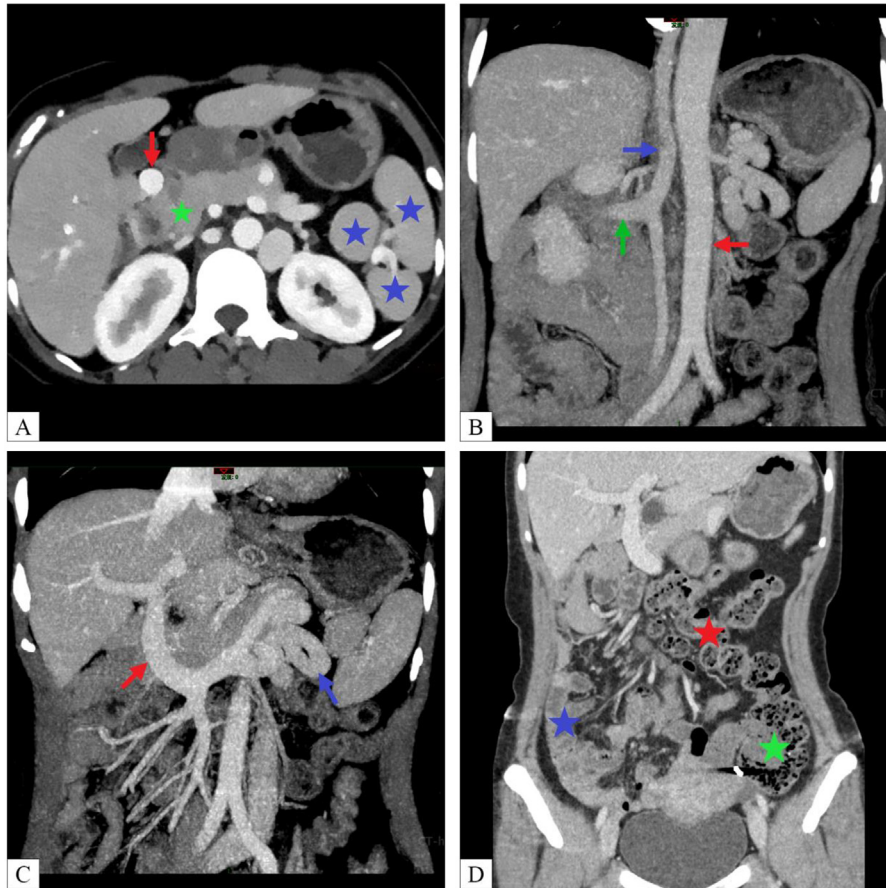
The patient’s abdomen CT scan images. (A) CT-enhanced Mono E40kev arterial phase image (axial plane). Multiple splenic nodules (blue stars) of varying sizes in the splenic area of the left upper abdomen. Part of the head and neck of the pancreas (green star) is hypertrophied and spherical, and the tail of the gland is short. The portal vein (red arrowhead) is located anterior to the duodenum. (B) CT MIP image (coronal plane). The right renal vein (green arrowhead) flows back into the azygos vein (blue arrowhead), and the azygos vein is located to the right of the abdominal aorta (red arrowhead). (C) CT MIP image (coronal plane). The anterior duodenal hepatic portal vein (red arrowhead) is enlarged and thickened, and the splenic vein (blue arrowhead) is enlarged and varicose. (D) CT MPR image (coronal plane). The horizontal segment of the duodenum does not cross the midline, the small intestine loops (blue star) are located in the right abdomen. The colon (red star) is in the left abdomen, and the ileocecal region (green star) is in the left lower abdomen.
